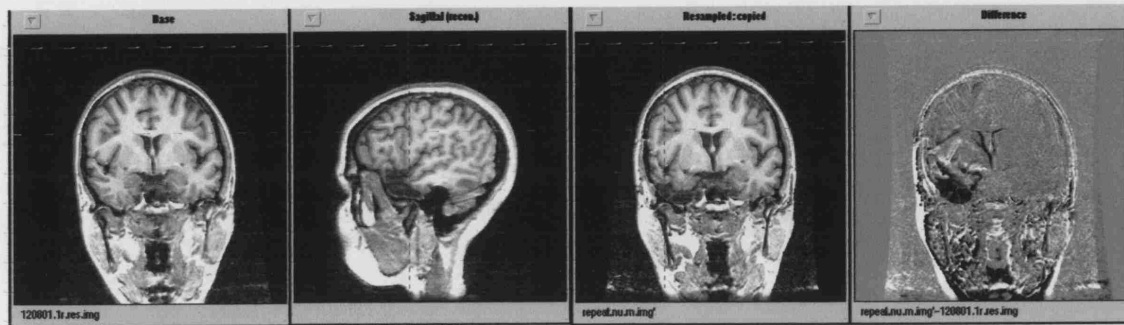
MR images from patient 11, a female with right hippocampal sclerosis and 20y of disease, showing the pre- and post-surgical images.
